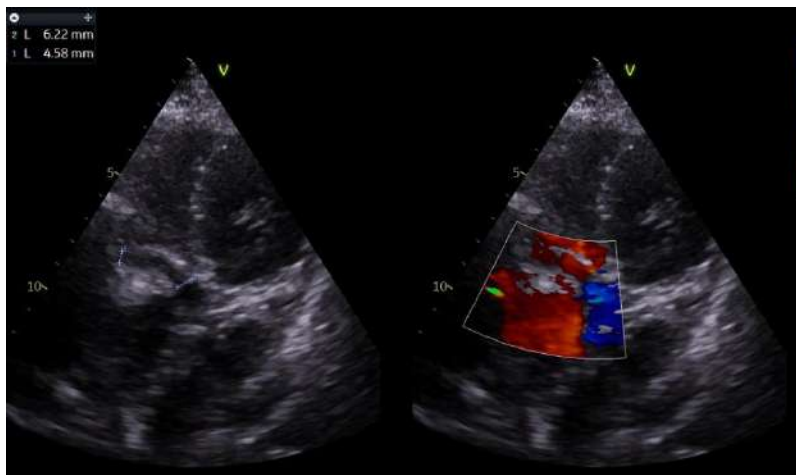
Transthoracic echo showed a short fistula formed by ruptured non coronary sinus to RA near right ventricular inflow part with dilated right atrium and left ventricle with good biventricular function.
